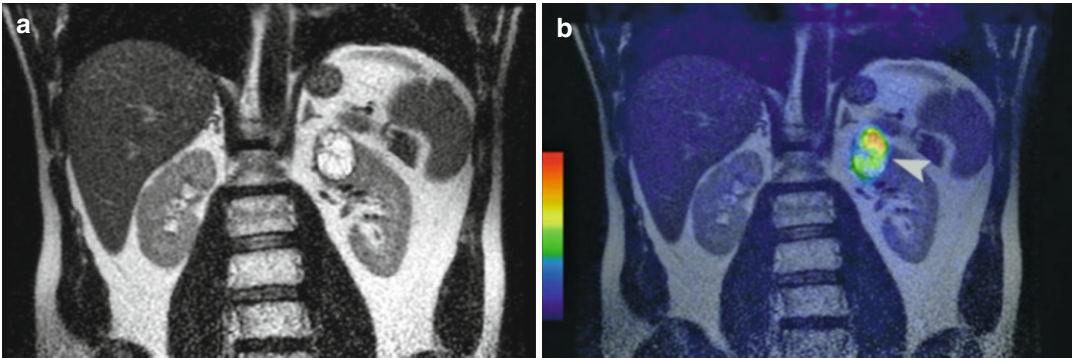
Patient with clear cell carcinoma, Fuhrman grade II/IV. Coronal T2-weighted MR image (a) shows a renal mass at the left upper pole. Fused iodine-124-labeled cg250
